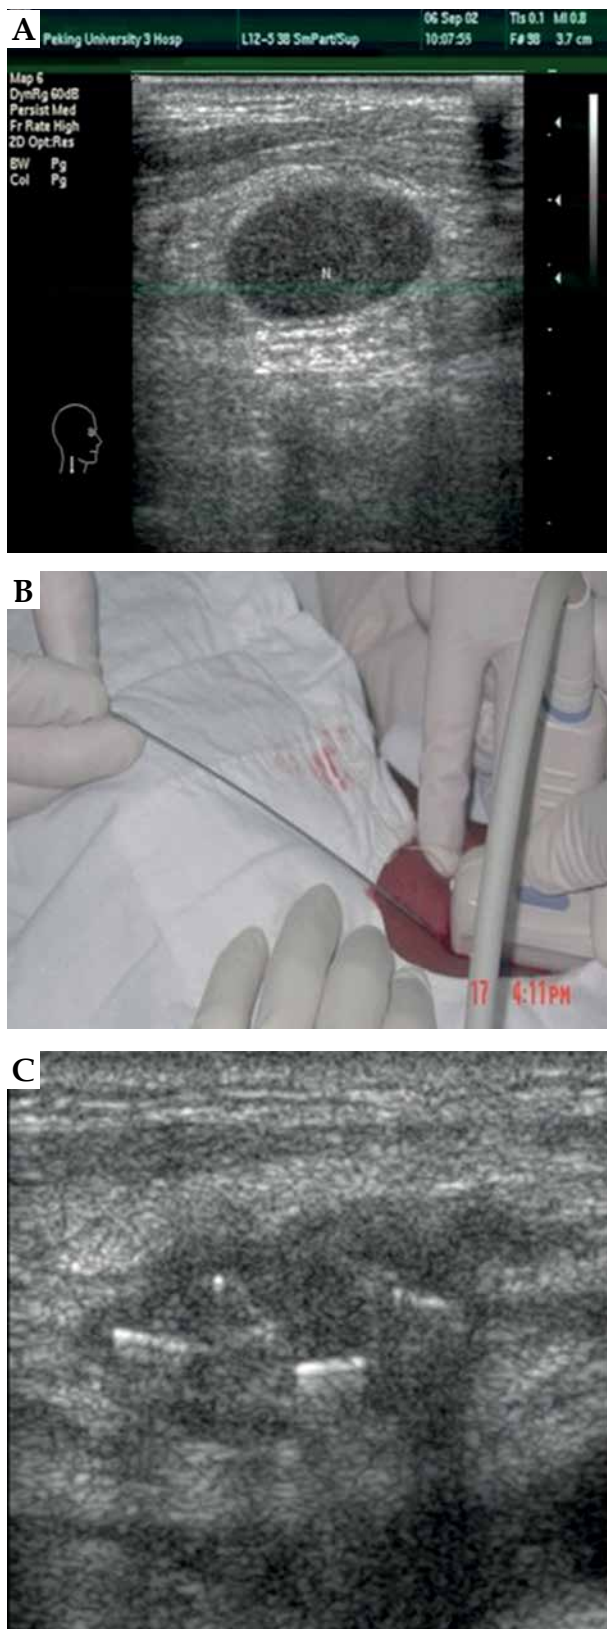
Patient with cervical lymph node recurrence of hypopharyngeal cancer. A) Ultrasound image of lymph node before ^{125}I seeds implantation; B) High frequency probe applied during seeds implantation; C) Seeds in ultrasound image after seeds implantation 1 month later
